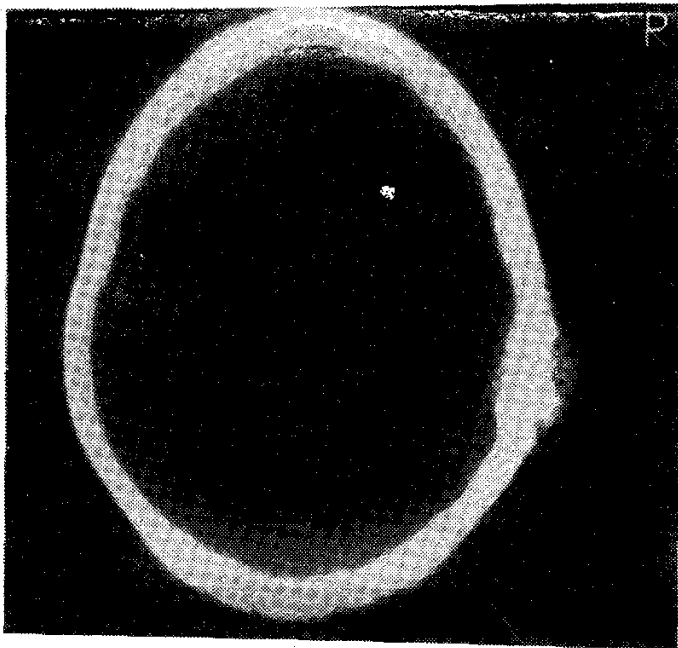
(a). Computed tomography bone window showing mixed density mass with bony spicules.
